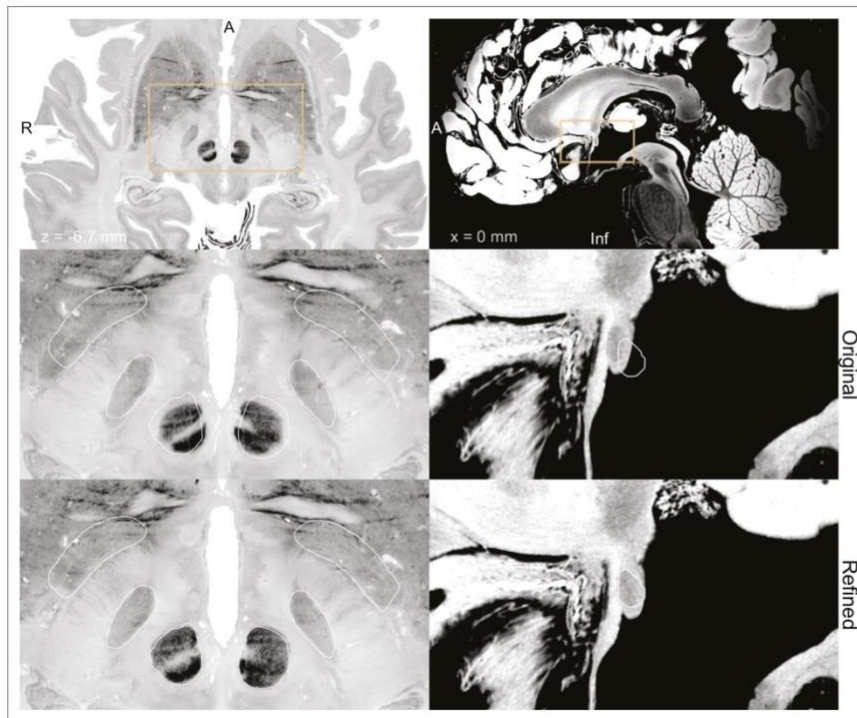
BigBrain (Amunts et al., 2013; Xiao et al., 2019) (left) and 7 T MRI ex vivo human brain template (Edlow et al., 2019) (right) are two high-resolution (100 μm isotropic) imaging resources that can be used from Lead-DBS and Lead-OR. The middle panel shows a closeup in a plane using the original transformation to MNI space (Xiao et al. in the case of BigBrain) with white outlines of DISTAL atlas (Ewert et al., 2018) (left) and anterior commissure from Neudorfer et al., 2020 (right). The bottom panel shows the same slice, but using a refined transformation using Lead-DBS and WarpDrive. The refined transformation files can be found in the supplementary data repository (Oxenford, 2022a).
